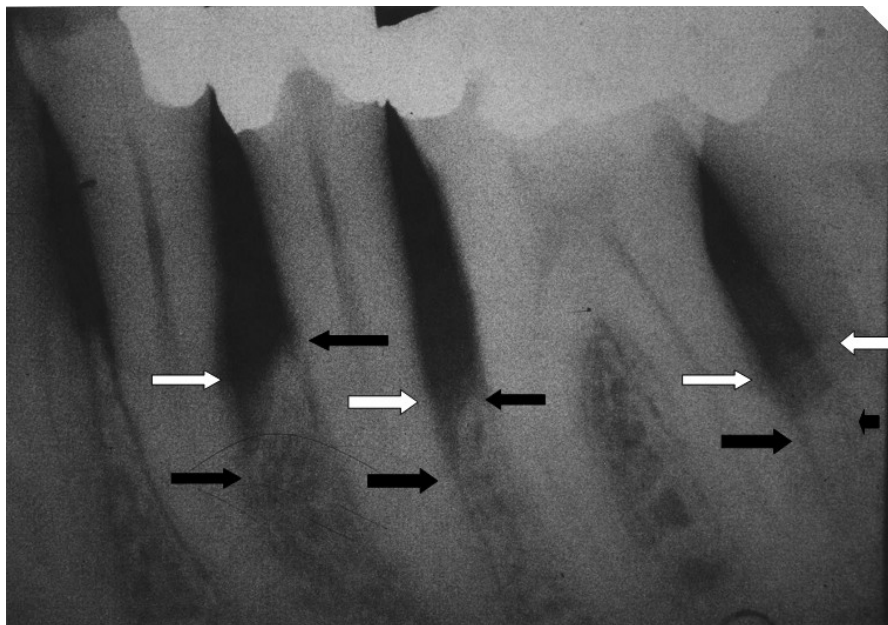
Radiograph of the same site taken 15 months postoperatively showing an increase in radiodensity in the infrabony defects but only partial infill of the defects. The radiodense material is diffuse and without trabeculations indicating that it had not matured into bone. (White arrows indicate change; black arrows show baseline.)
